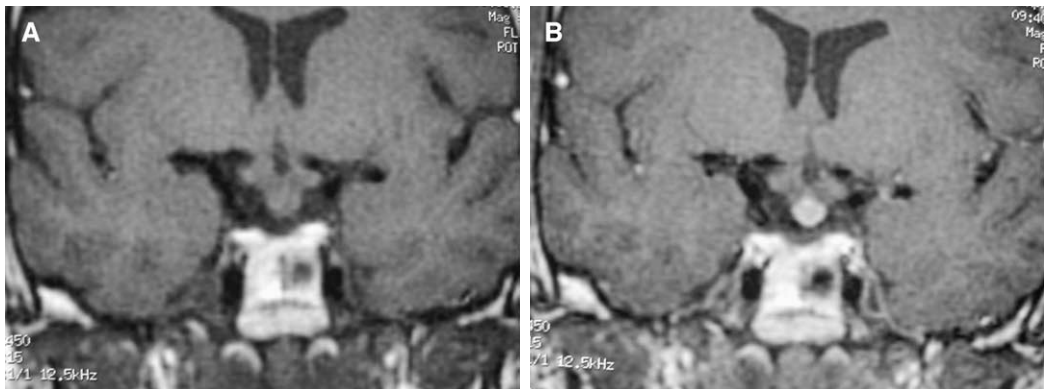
Sarcoidosis. (A) Coronal T1-weighted image demonstrates a suprasellar isointense mass. (B) Coronal postcontrast T1-weighted image shows intense enhancement of the mass just inferior to the optic chiasm.
